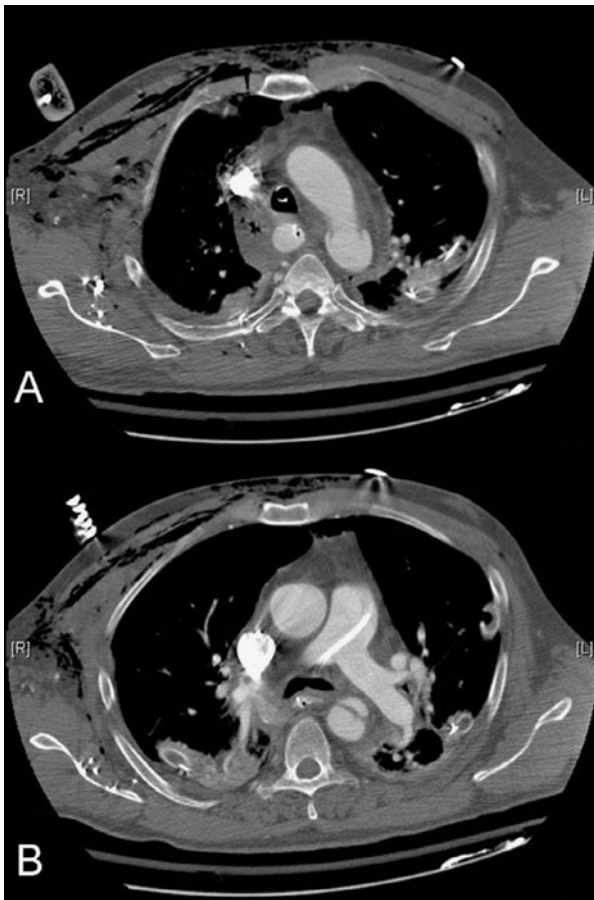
Helical computed tomography scan of the chest in a 30-year-old male after a high-speed motor vehicle accident. Slice A demonstrates circumferential disruption of the aortic wall just beyond the left subclavian. Slice B demonstrates an intimal flap in the proximal descending thoracic aorta. Both slices demonstrate periaortic hematoma.
